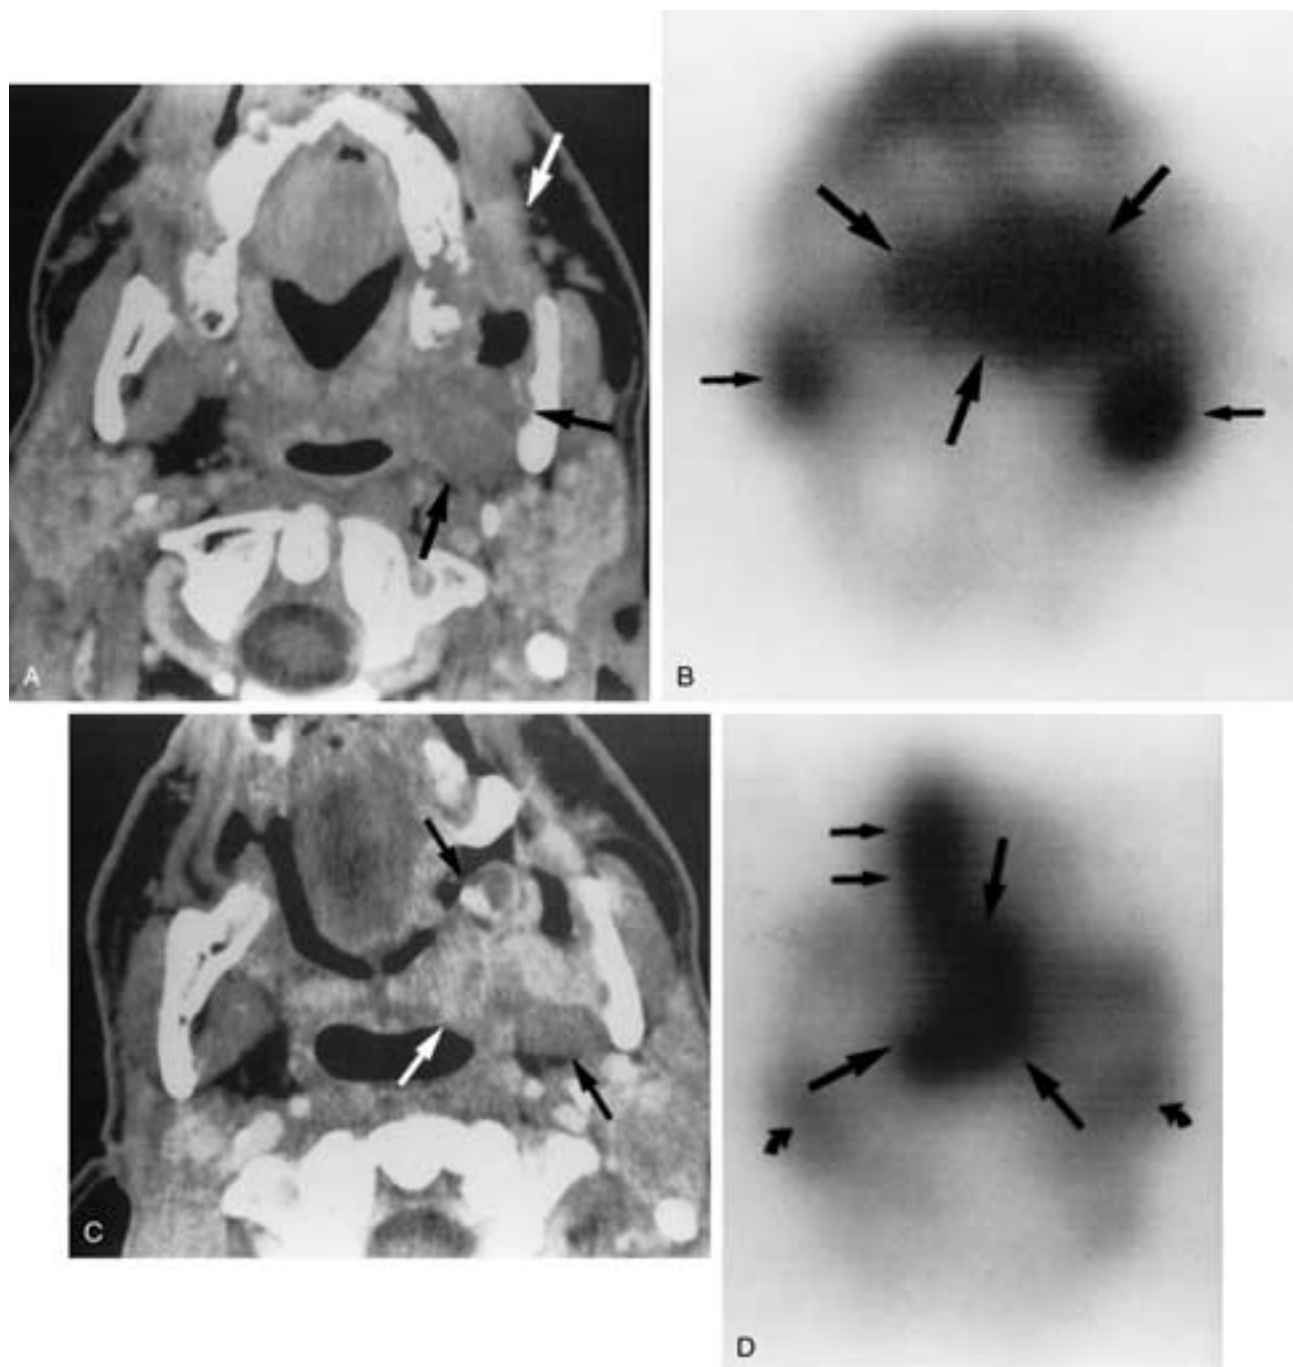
Local failure following nonsurgical organ preservation therapy. A, Axial pretreatment contrast-enhanced CT image demonstrates an SCC involving the left tonsil that extends deeply to involve the masticator space (*arrows*). B, Axial image from a pretreatment thallium-201 SPECT study obtained at approximately the same level as A shows an area of abnormal radiotracer uptake corresponding to the abnormality seen on CT (*large arrows*). Normal parotid gland uptake (*small arrows*). C, CT scan performed 6 weeks after completion of treatment demonstrates a persistent mass in the region of the primary site (*arrows*). D, Posttreatment thallium study obtained at approximately the same level as C shows persistent abnormal radiotracer uptake 6 weeks after completion of therapy (*large arrows*). This patient had biopsy-proven persistent disease at the primary site 6 weeks after completion of therapy. Note the reduction in parotid gland uptake following treatment (*curved arrows*). Probable nasal mucosa uptake (*small arrows*). (From Mukherji SK, Gapany M, Neelon B, et al. Evaluation of ^{201}Tl SPECT for predicting early treatment response in patients with squamous cell carcinoma of the extracranial head and neck treated with nonsurgical organ preservation therapy: Initial results. *J Comput Assist Tomogr* 2000;24:146–151.)
